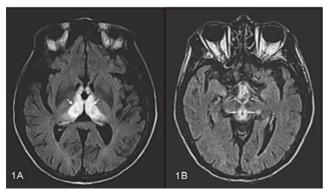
Axial image of brain magnetic resonance image one week after the patient's onset of Wernicke's encephalopathy. (A) Fluid attenuated inversion recovery (FLAIR) images showed hyperintense lesions involving the circumventricular nuclear regions in the thalamus (arrows). (B) Increased signal was found in both mamillary bodies (arrows) and periaqueductal gray matter (arrowheads) on FLAIR images.
